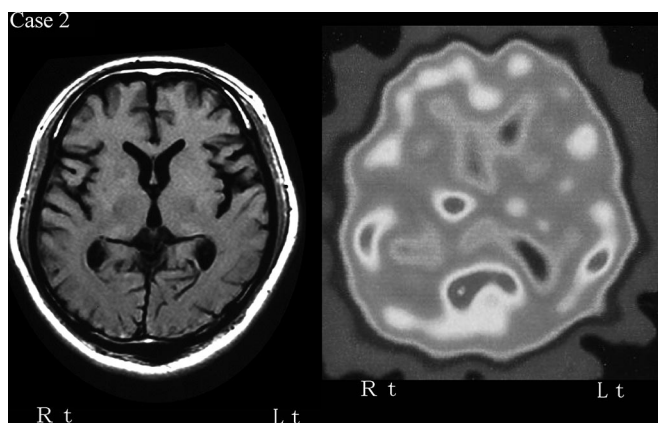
MRI and SPECT findings of case 2. Left: T1-weighted MR image (TR/TE = 450/18.0 milliseconds). Right: ^{123}I -IMP (early image).
